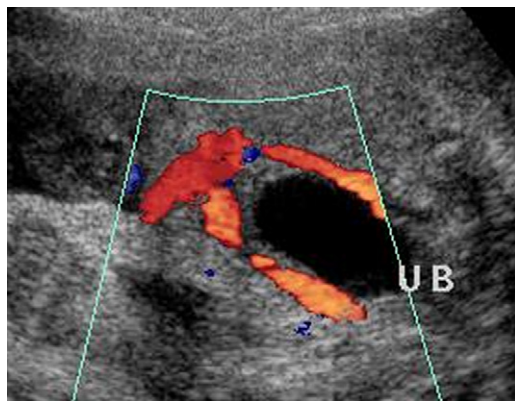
Axial color Doppler image demonstrates the normal urinary bladder (UB) flanked by umbilical arteries.
